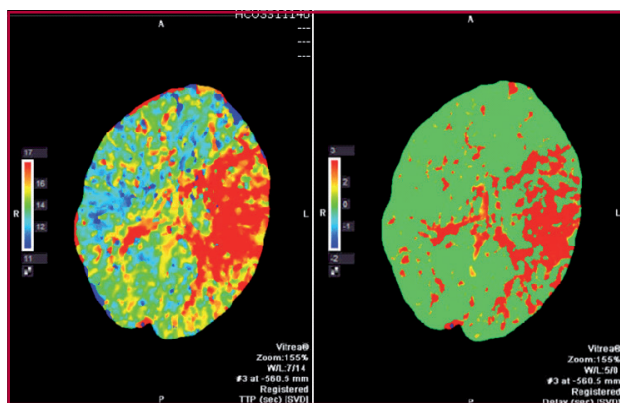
CT-perfusion images showing a large ischemic area in the territory of the left medial cerebral artery occlusion with preserved cerebral blood volume indicating the persistence of recoverable tissue.
